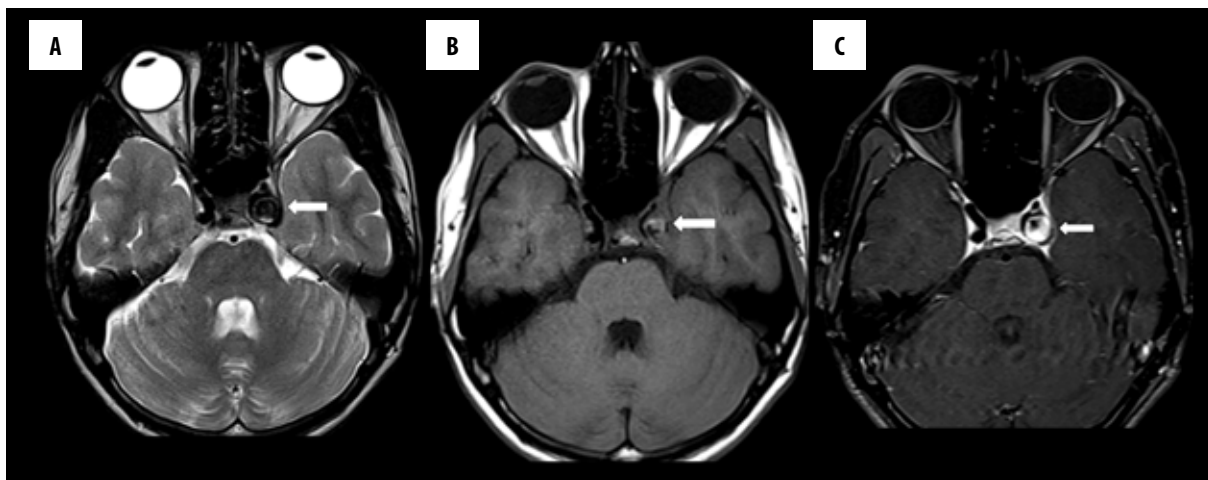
Axial T2-weighted (A), T1-weighted (B), T1-weighted post-contrast fat saturation (C) MR images show an aneurysm in the left ICA cavernous segment (arrows). Note that the lumen of the aneurysm is hyperintense on T1-weighted images and is filling with contrast on post-contrast images.
